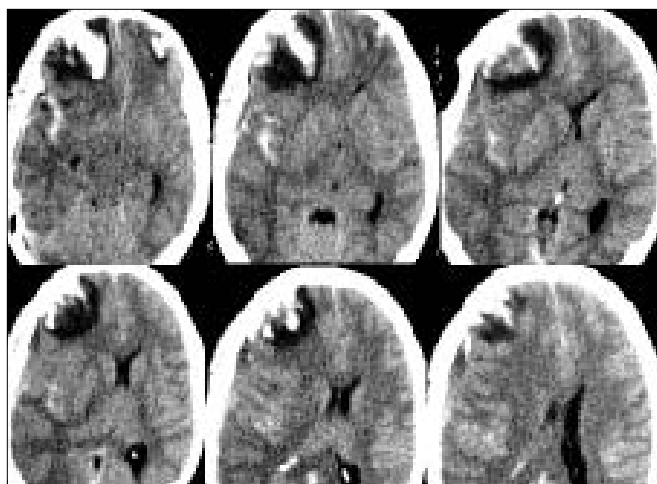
Second CT scan of case 1 showing no significant increase in ICH
